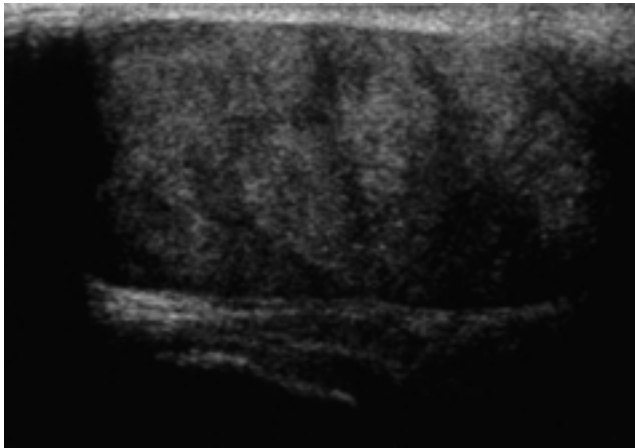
Perineal ultrasonogram reveals about 5 cm-sized, homogeneously hypoechoic mass in right vulvar area.
